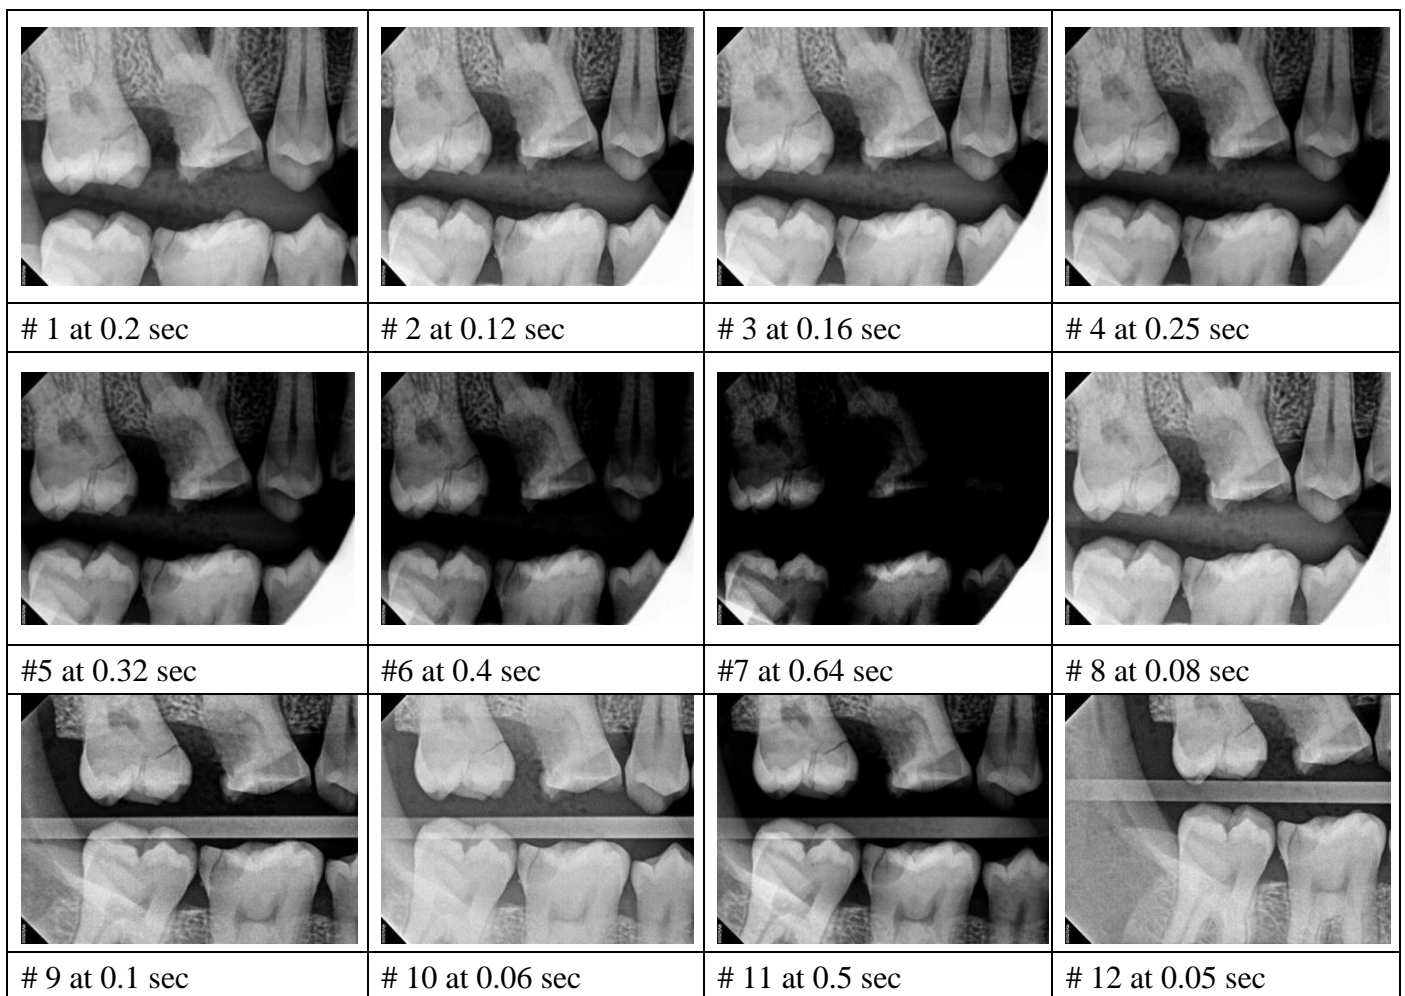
Image quality assessment has taken at different exposure time's and 40 cm SID using RVG 5200 sensor for bitewing projection.
